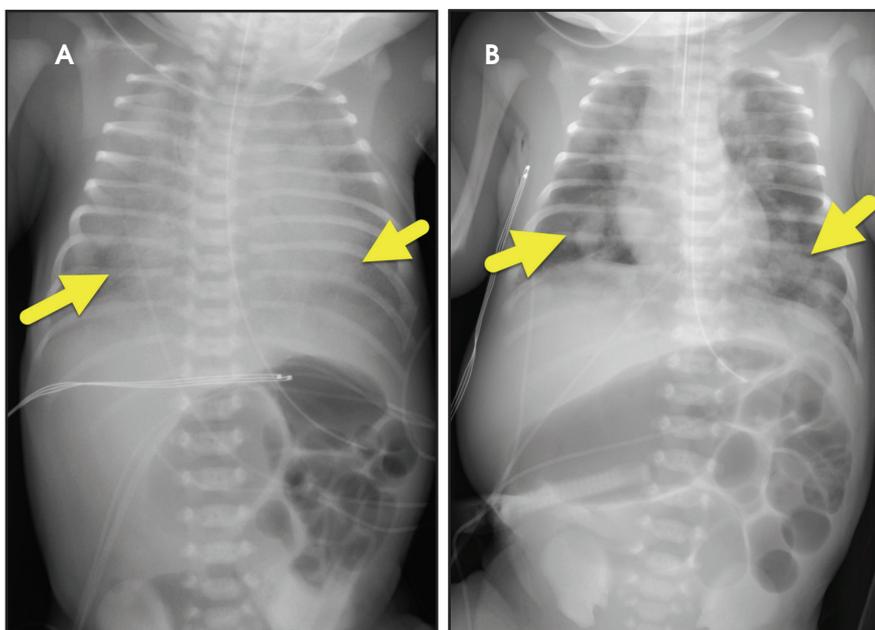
Abdominal radiographs at birth (A) and at 1 day of life (B) demonstrate persistent dilated loops of bowel with paucity of bowel gas in the rectum. Multiple pulmonary lesions are also present (arrows).
